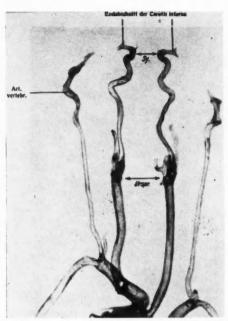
A radiographic study of dissected arteries showing plaque formation at sites of predilection. Note occurrence of plaque formation in the carotid syphon and at areas of branching. (Reproduced from dei Poli and Zucha. 35 (By kind permission of the publishers).
